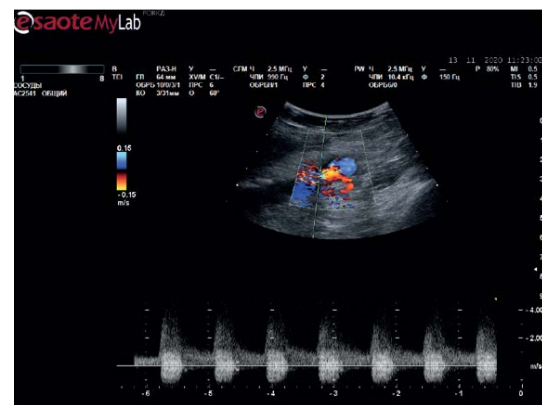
Angioscanogram (spectral Doppler mode): hemodynamically significant stenosis at the level of the second branch of the deep femoral artery
